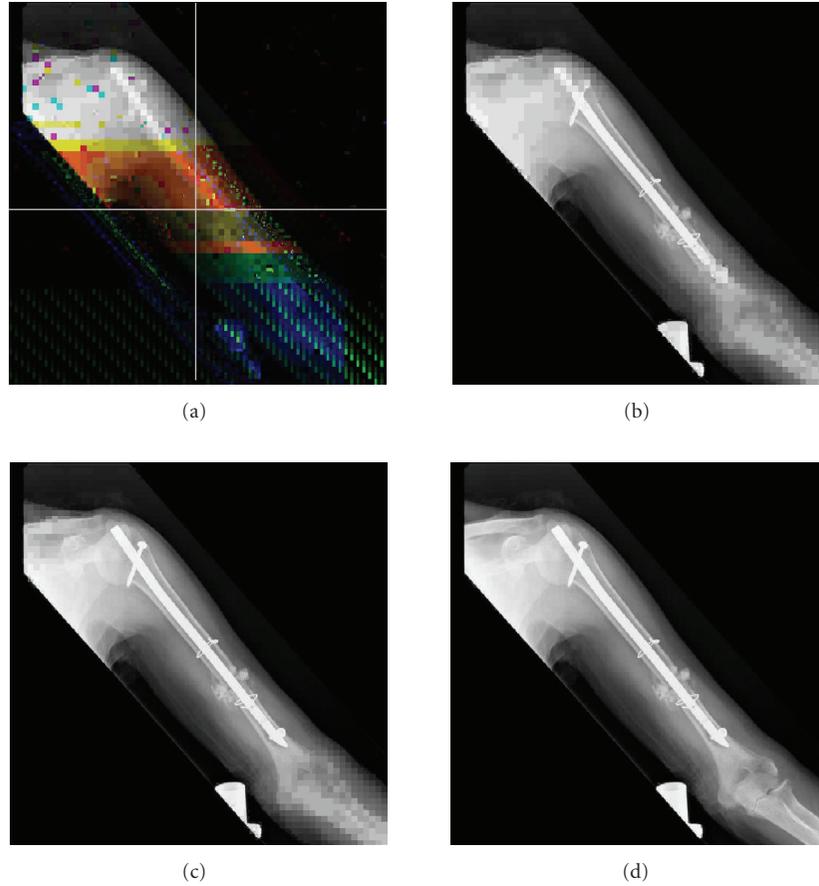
As another example, a decoded image with variable length parity, which is a 508×512 pixels monochrome X-ray bone image: (a) a background image and the location of ROI selected in the center of image reconstructed after stage P_1 ; many subblocks are in error in the background image, (b) the reconstructed image after stage P_2 , no error subblock is found in the reconstructed image. (c) The reconstructed image after stage P_3 , and (d) the complete transmitted image having no error subblocks.
